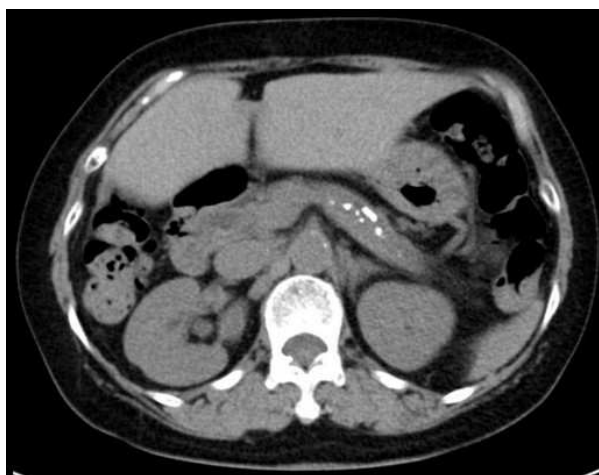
Abdominal CT showing multiple pancreatic stones in an atrophic pancreas.
